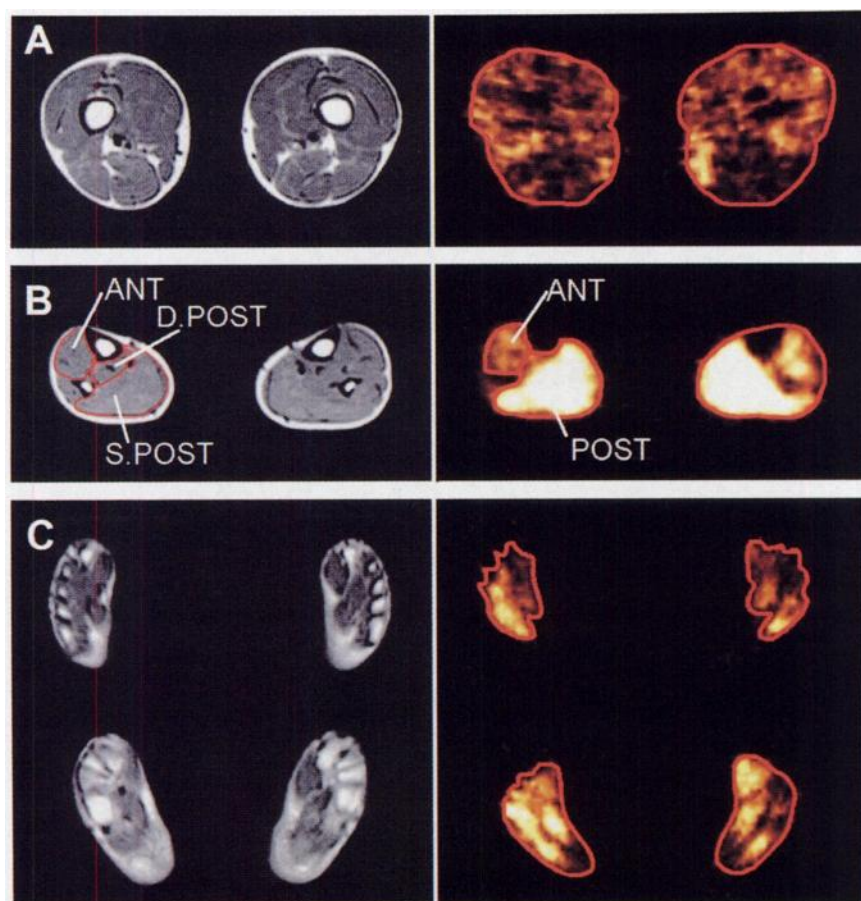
Transverse MR and PET images of thighs (A), legs (B) and feet (C). ROI for thigh was defined along surface line of thigh region as shown in A, right panel. ROIs for leg and foot were defined in similar fashion (B and C). ROI for anterior (ANT) compartment of leg was defined based on MR images. ROI for posterior compartment of leg measured FDG uptake of both superficial (S.POST) and deep (D.POST) posterior compartments. Region lateral to fibula is lateral compartment and was not measured in this study.
